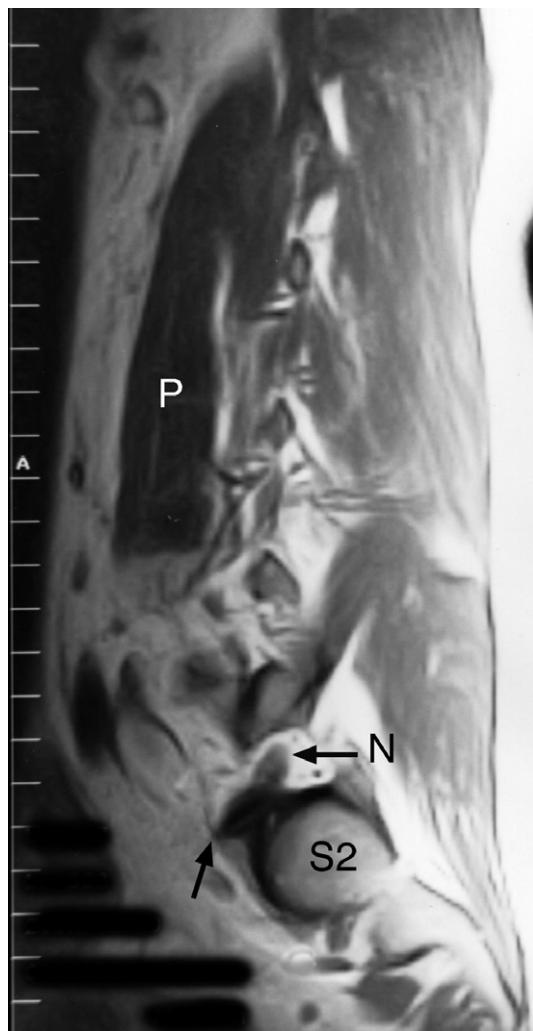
Lumbar spine MRI left parasagittal T1-weighted image including the left side of the lumbosacral spine at the S1-2 level. Note the nerve root (N) in the S1-2 foramen before it passes the osteophytes (black arrow) on the lateral side of the S1-2 level. P = psoas muscle.
